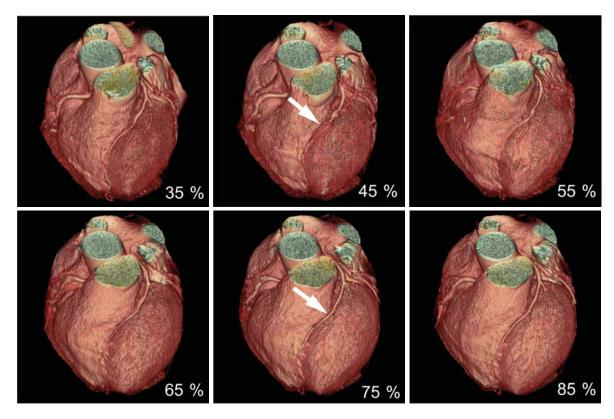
Image quality in different phases of coronary CT angiography (35%, 45%, 55%, 65%, 75%, 85% of R-R interval). The 3D volume rendering of patient undergone coronary CT angiography below 60 bpm of heart rates demonstrates the best and worse image quality of LAD at 75% and 45% of R-R interval (arrow), respectively
